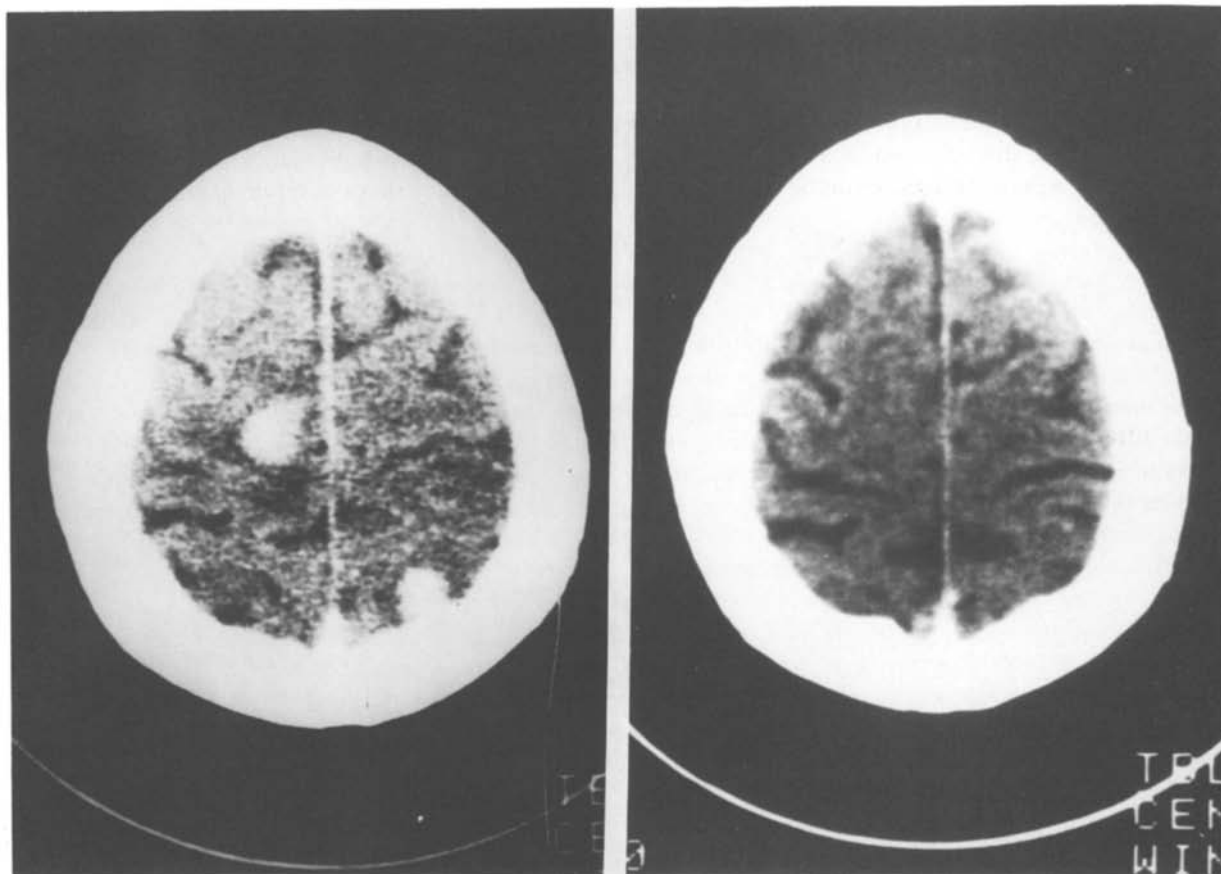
Left: A 65-year-old woman with melanoma and multiple cerebral metastases. After this scan, she received 3000 rad whole-brain radiation therapy; Right: Follow-up CT scan 10 weeks later showed complete resolution of metastases.
